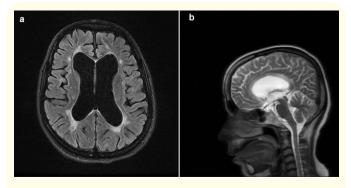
a: Axial FLAIR- T2-weighted MRI and b: Sagittal T2-weighted MRI image showing widening of brain ventricles, disproportionate to brain atrophy.
